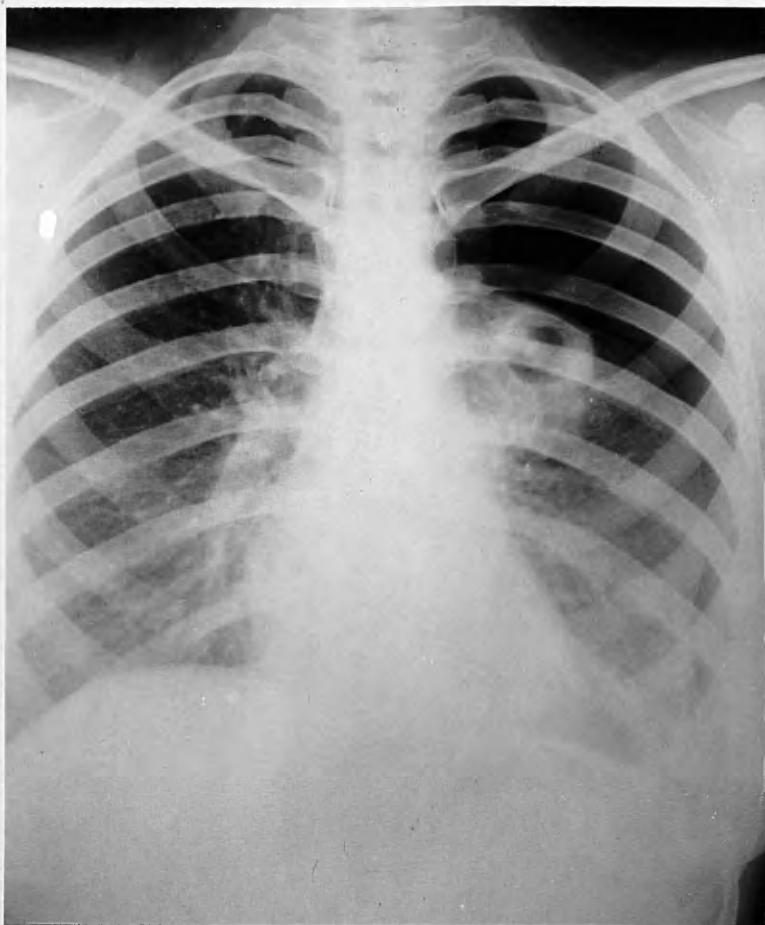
Radiograph taken on 22.1.52. showing a large cavity still present in an atelectatic left upper lobe, despite treatment for six months by artificial pneumothorax.
